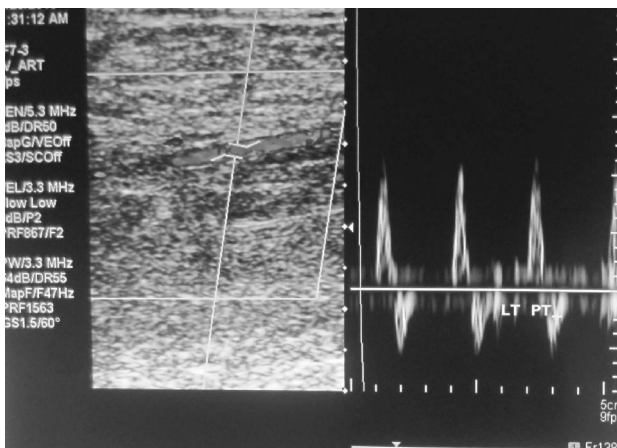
Colour Doppler imaging of lower limb showing atherosclerotic changes with dampened flow (arrow).
